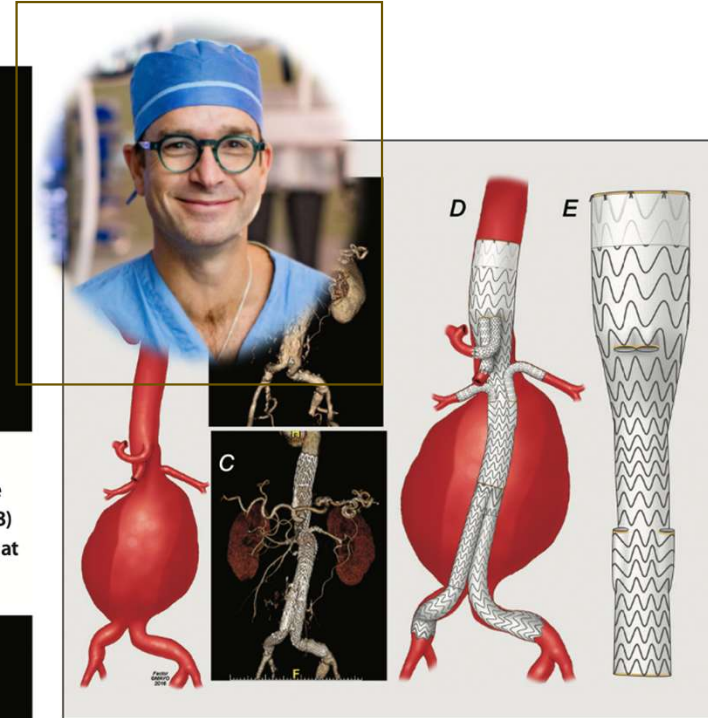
The third worldwide and first United States case performed at the Mayo Clinic in Rochester, Minnesota, by Dr. Gustavo Oderich and colleagues. Artist depiction shows the aneurysm (A) and preoperative (B) and postoperative (C) CTA. Artist depiction of the treated aneurysm (D) and the GORE[®] EXCLUDER[®] Thoracoabdominal Branch Endoprosthesis (E).
